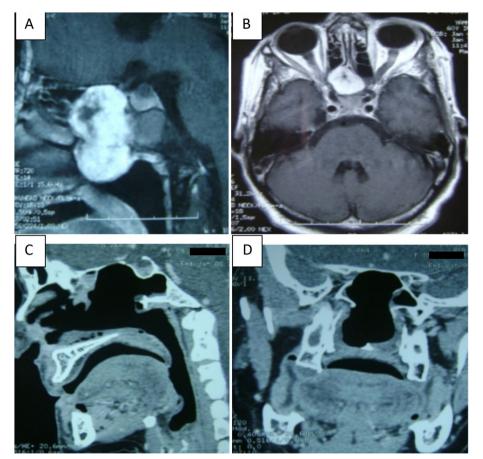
Case 3. Sphenoid sinus chondroma. MRI sagittal view (A upper left) showing a tumor of the sphenoid sinus expanded to the rhinopharynx with no intracranial involvement. On MRI axial view (B upper right), the tumor does not involve surrounding structures. Postoperative CT scan sagittal view (C lower left) and coronal view (D lower right) showing a total removal of the sphenoid sinus tumor
